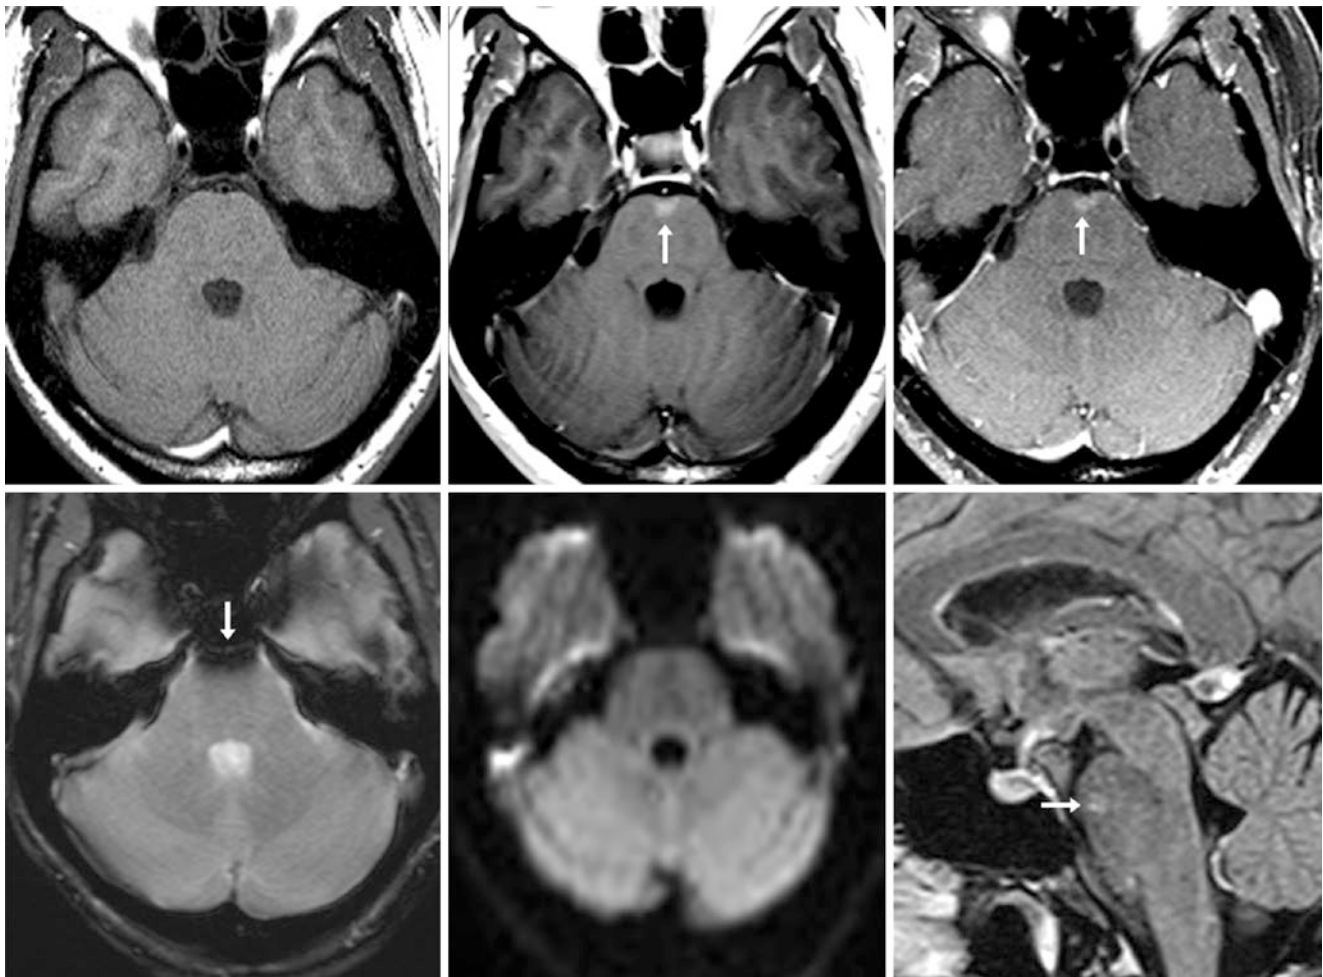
A 39 year old with hearing loss underwent a 1.5T MRI that included a normal-appearing precontrast T1WI (*top left*). There was faint enhancement of a ventral pontine BCT (*arrows*) on postcontrast GE T1WI (*top middle*) and on SE T1WI (*top right*). This is obscured on
